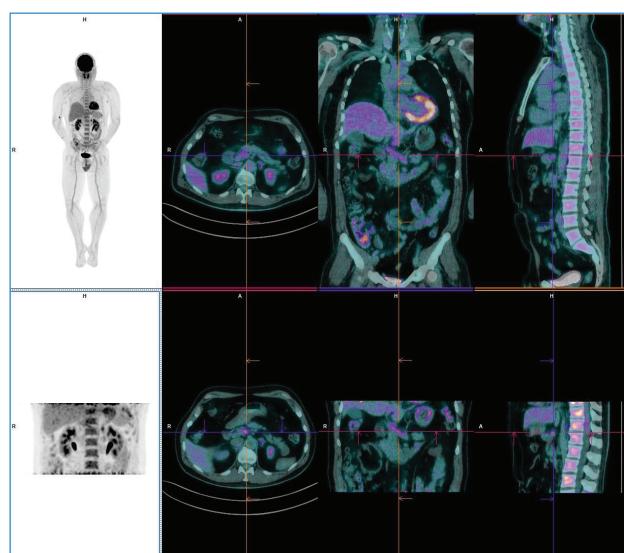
PET scan com FDG mostra aumento difuso moderado e relativamente homogêneo da captação do radiofármaco em todo o trajeto da artéria hepática comum (ver ponto focalizado), tanto no estudo inicial (painéis superiores) como nas imagens tardias, (painéis inferiores).
